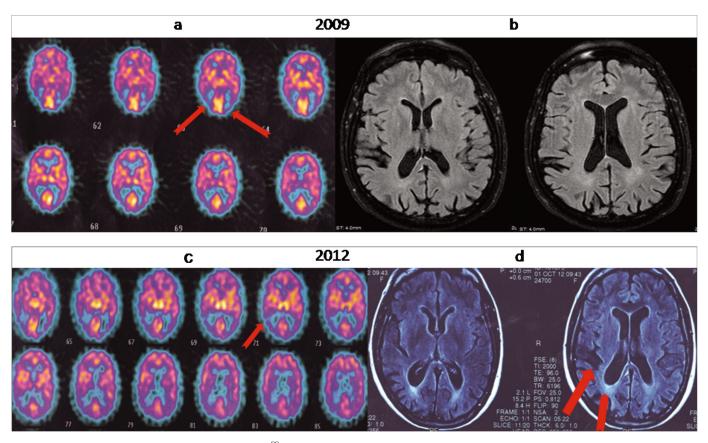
Brain Scans and Imaging. In 2009, a perfusional ^{99m}Tc-ECD-SPECT brain scan of the patient revealed bilateral hypoperfusion of the visual association cortices (arrows) (A). Brain magnetic resonance imaging revealed hyperintensities of the optical radiations and bilateral parieto-occipital atrophy (B). In 2012, ^{99m}Tc-ECD-SPECT revealed an area of perfusional deficit within the post-central right lobule (arrow) (C). MRI revealed atrophy of the post-central parietal lobule (thick arrow) and increased and asymmetric dilatation of the posterior horn of the right lateral ventricle (small arrow) (D).
